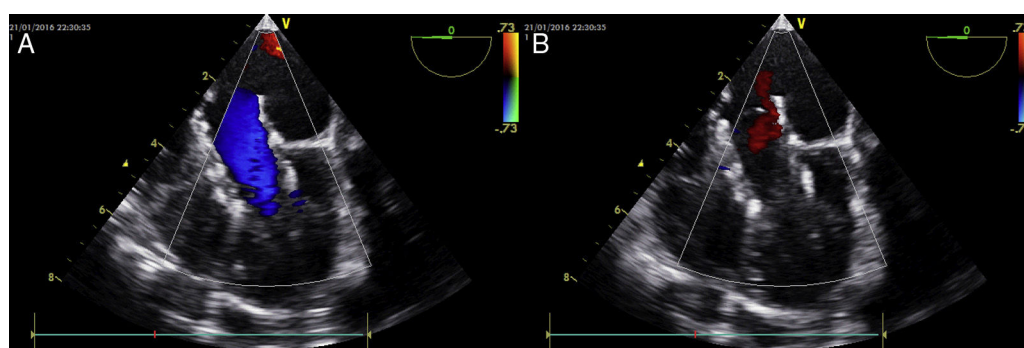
Transesophageal echocardiogram showing absence of stenosis (A) and regurgitation (B) with the implanted valve.
